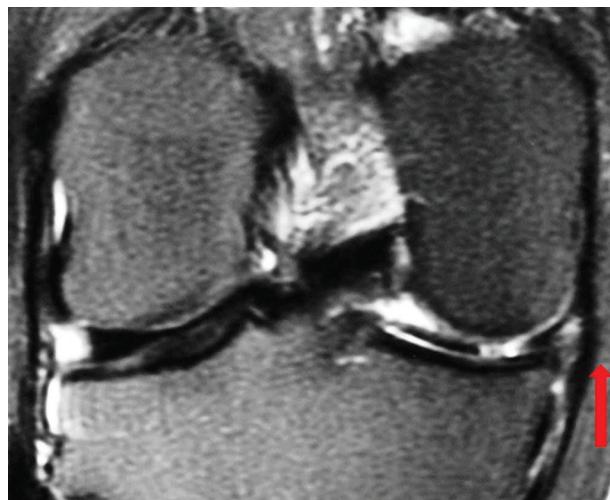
Magnetic resonance imaging (MRI)scan of the knee demonstrating a posteromedial meniscal injury.
